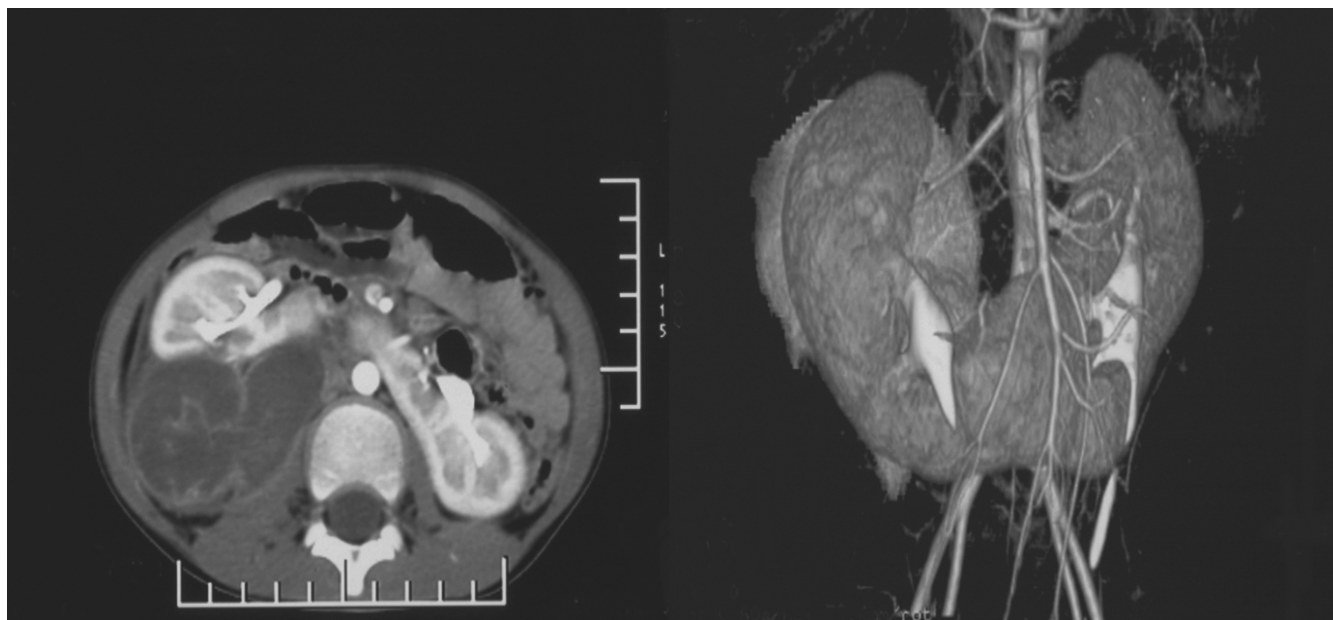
Pre-surgery 64 row of spiral Computed tomographic scan of abdomen showing large retroperitoneal mass associated with horseshoe kidney.
